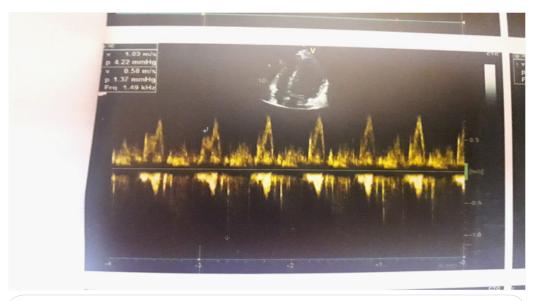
4-D Echocardiogram showing mitral valve velosity-1.03m/s,peak gradient-1.37mmHg.
